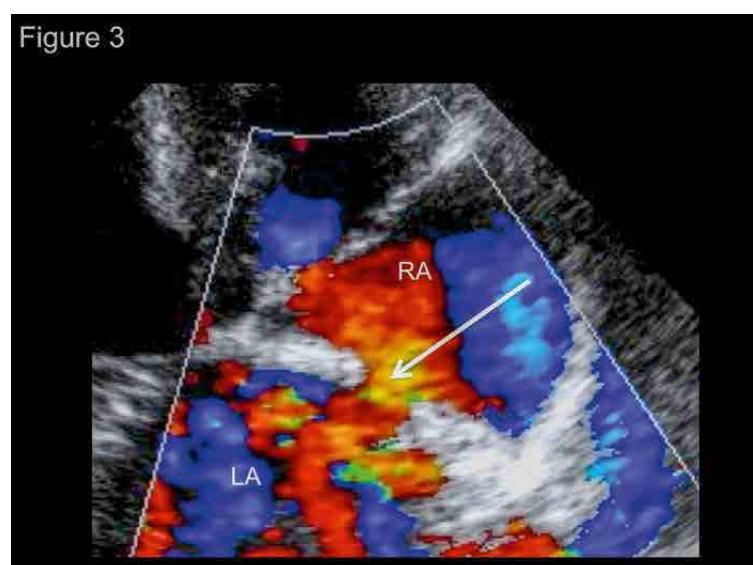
Recording of the flow through the acquired atrial septal defect, using color-flow Doppler mode from the right parasternal long axis 4-chamber view. The shunting flow was continuously left-to-right (with peak velocities of 2.2 m/s in systole and 1.1 m/s in diastole). LA, left atrium; RA, right atrium.
